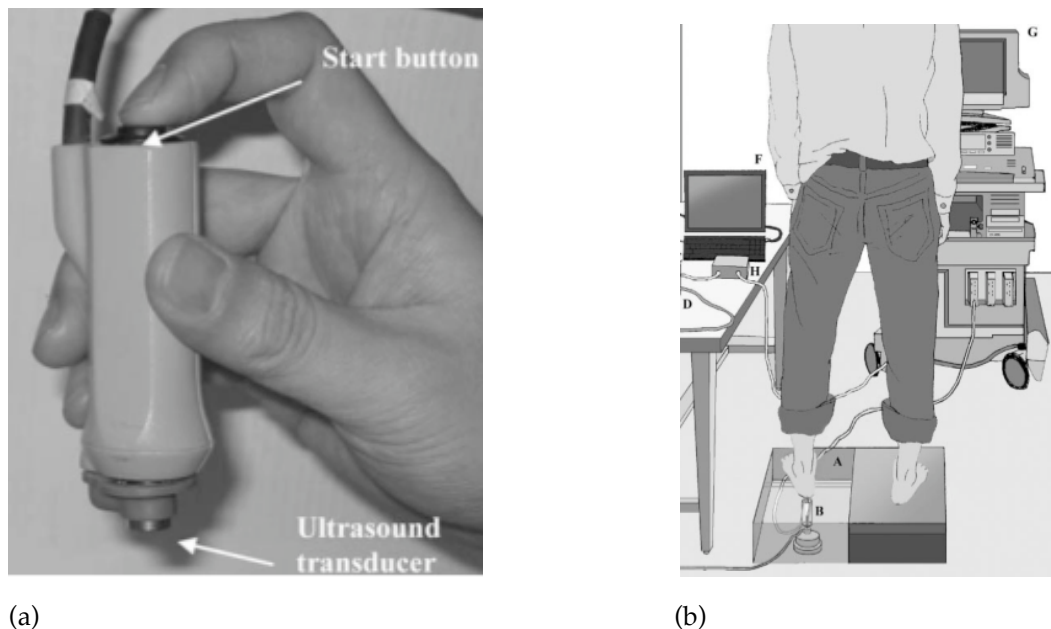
(a) Hand held indentation system with an ultrasound probe. (Ling et al., 2007). (b) Subject on a platform (A) composed by a couple of an ultrasound transducer and a load cell (B). (Hsu et al., 2007).
